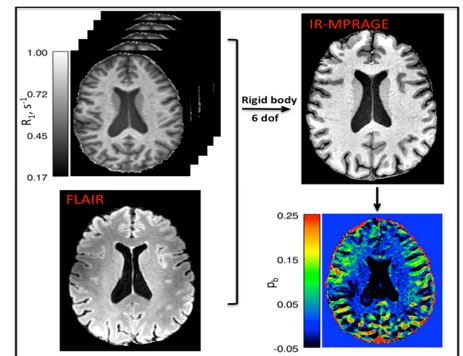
R₁ maps and FLAIR images are co-registered to the anatomic MPRAGE images.
